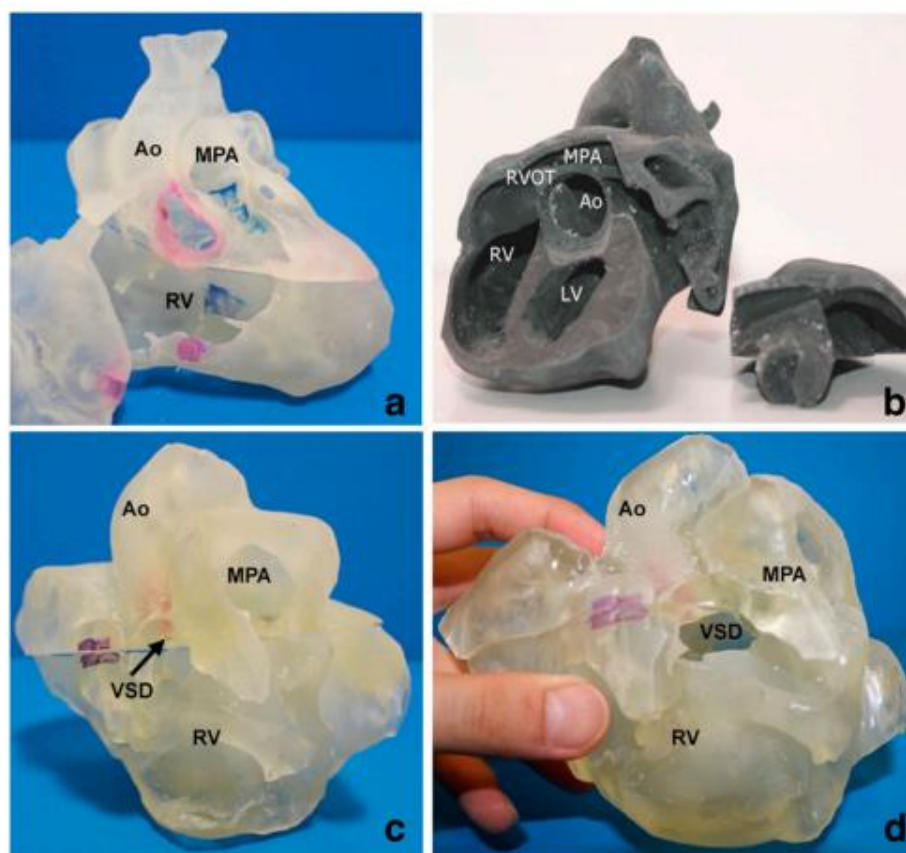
3D printed heart models showing normal anatomy and pathology. (a) Normal heart model created from cardiac CT and is partitioned into three pieces allowing visualization of interventricular septum. (b) Repaired Tetralogy of Fallot (ToF) from an adult patient. The model was created from cardiac magnetic resonance imaging (MRI) and separated into two pieces allowing for clear visualization of overriding aorta and pulmonary infundibular stenosis. (c) Unrepaired ToF heart model from an infant. The model was created from 3D echocardiographic images and partitioned into two pieces showing the ventricular septal defect (VSD). (d) Unrepaired ToF heart model from an infant with superior and inferior portions showing VSD and the aortic overriding in relation to the VSD. Reprinted with permission under the open access from Loke et al. [22]. Ao—Aorta; MPA—Main Pulmonary Artery; LV—Left Ventricle; RV—Right Ventricle; RVOT—Right Ventricular Outflow Tract; VSD—Ventricular Septal Defect; ToF—Tetralogy of Fallot.
